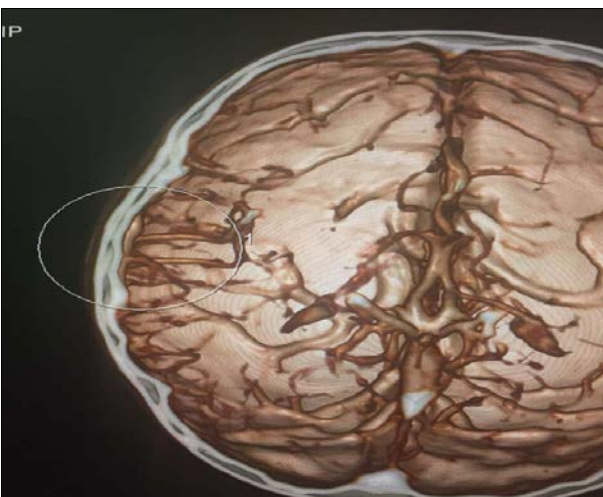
CT angiography digital subtraction angiography (DSA). show the connection transverse sinus
